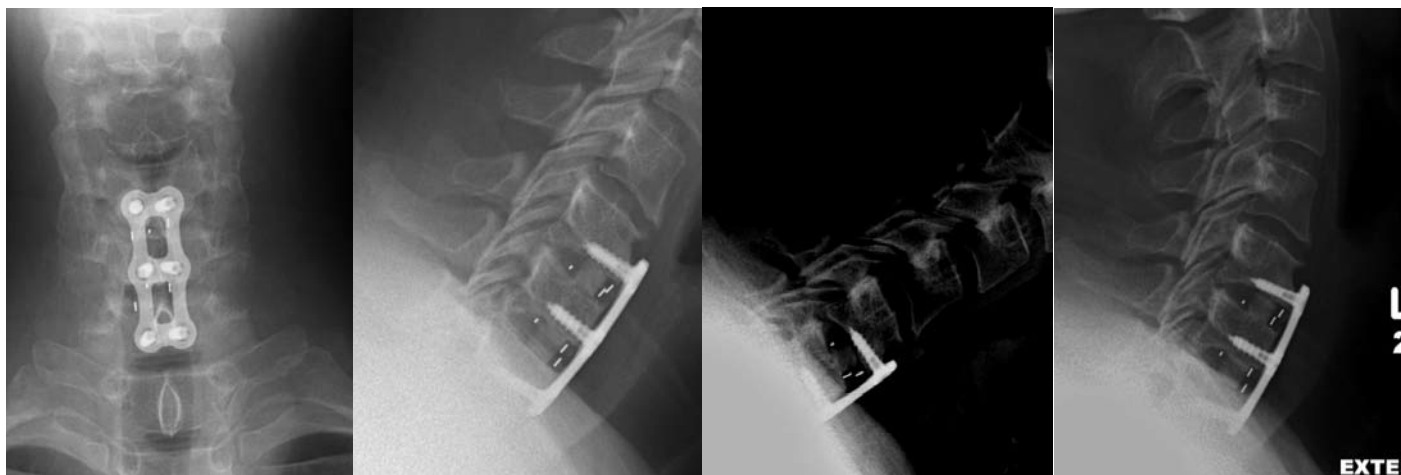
AP, Lateral, and Flexion-Extension x-rays at 12 month follow-up
